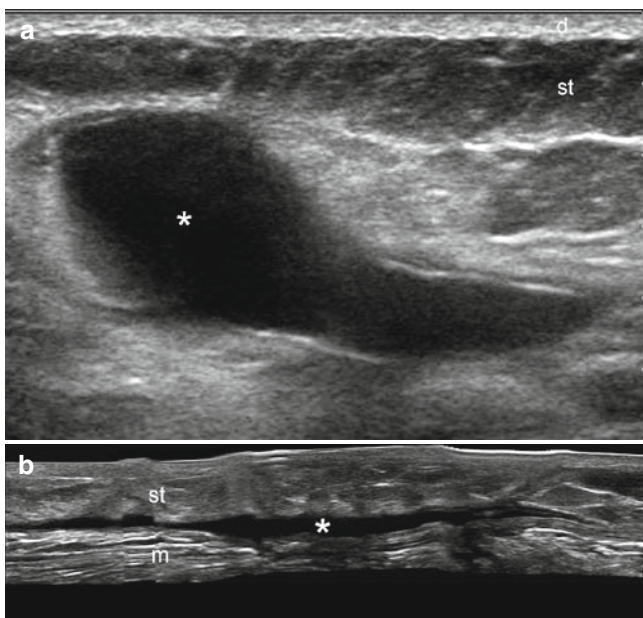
(a, b). Serohematoma. (a) Grey scale ultrasound image (transverse view; lateral aspect of the left thigh) shows a well-defined anechoic fluid collection (*) in the subcutaneous tissue (post-trauma). Increased echogenicity of the surrounding subcutaneous tissue is also detected. (b) Grey scale ultrasound image (transverse view; abdominal wall; hypogastrum region) demonstrates anechoic band of fluid (*) in the deep subcutaneous tissue (post-abdominoplasty). Increased echogenicity of the subcutaneous tissue (st) is also seen in the vicinity of the collection. *Abbreviations:* d dermis, st subcutaneous tissue, m rectus abdominis muscle
